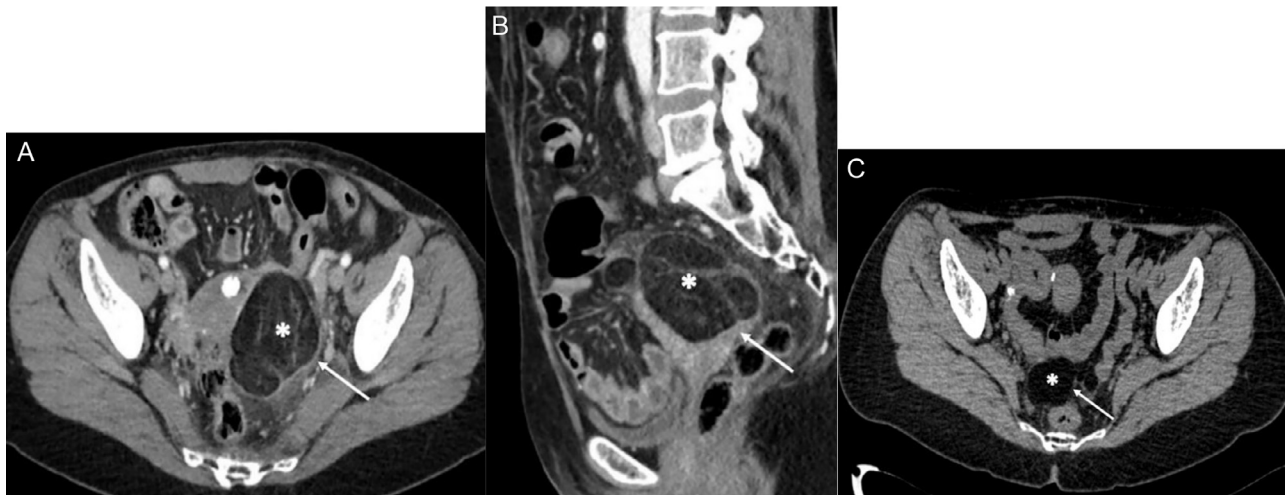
A and B. Contrast-enhanced CT of the abdomen and pelvis: showed a large fat-containing mass next to the sigmoid colon (asterisk) surrounded by fat stranding (arrow). C. Contrast-enhanced CT of the abdomen and pelvis: performed 7 years before the admission were retrieved from our digital archive and the comparison demonstrated that the lesion (asterisk) was smaller and located medial and posterior within the pelvis; and there was no fat stranding (arrow).
